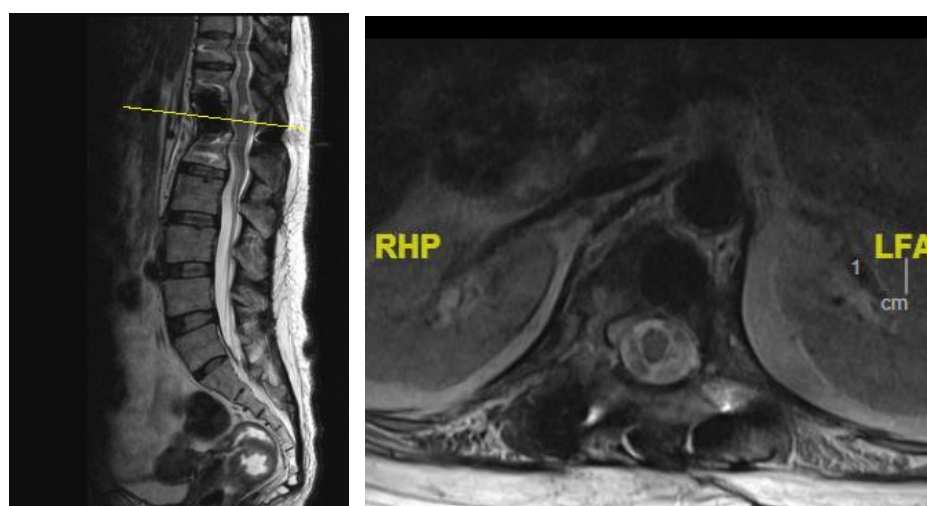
Post-treatment MRI lumbo-sacral demonstrating resolved spine infection and paravertebral collection.
